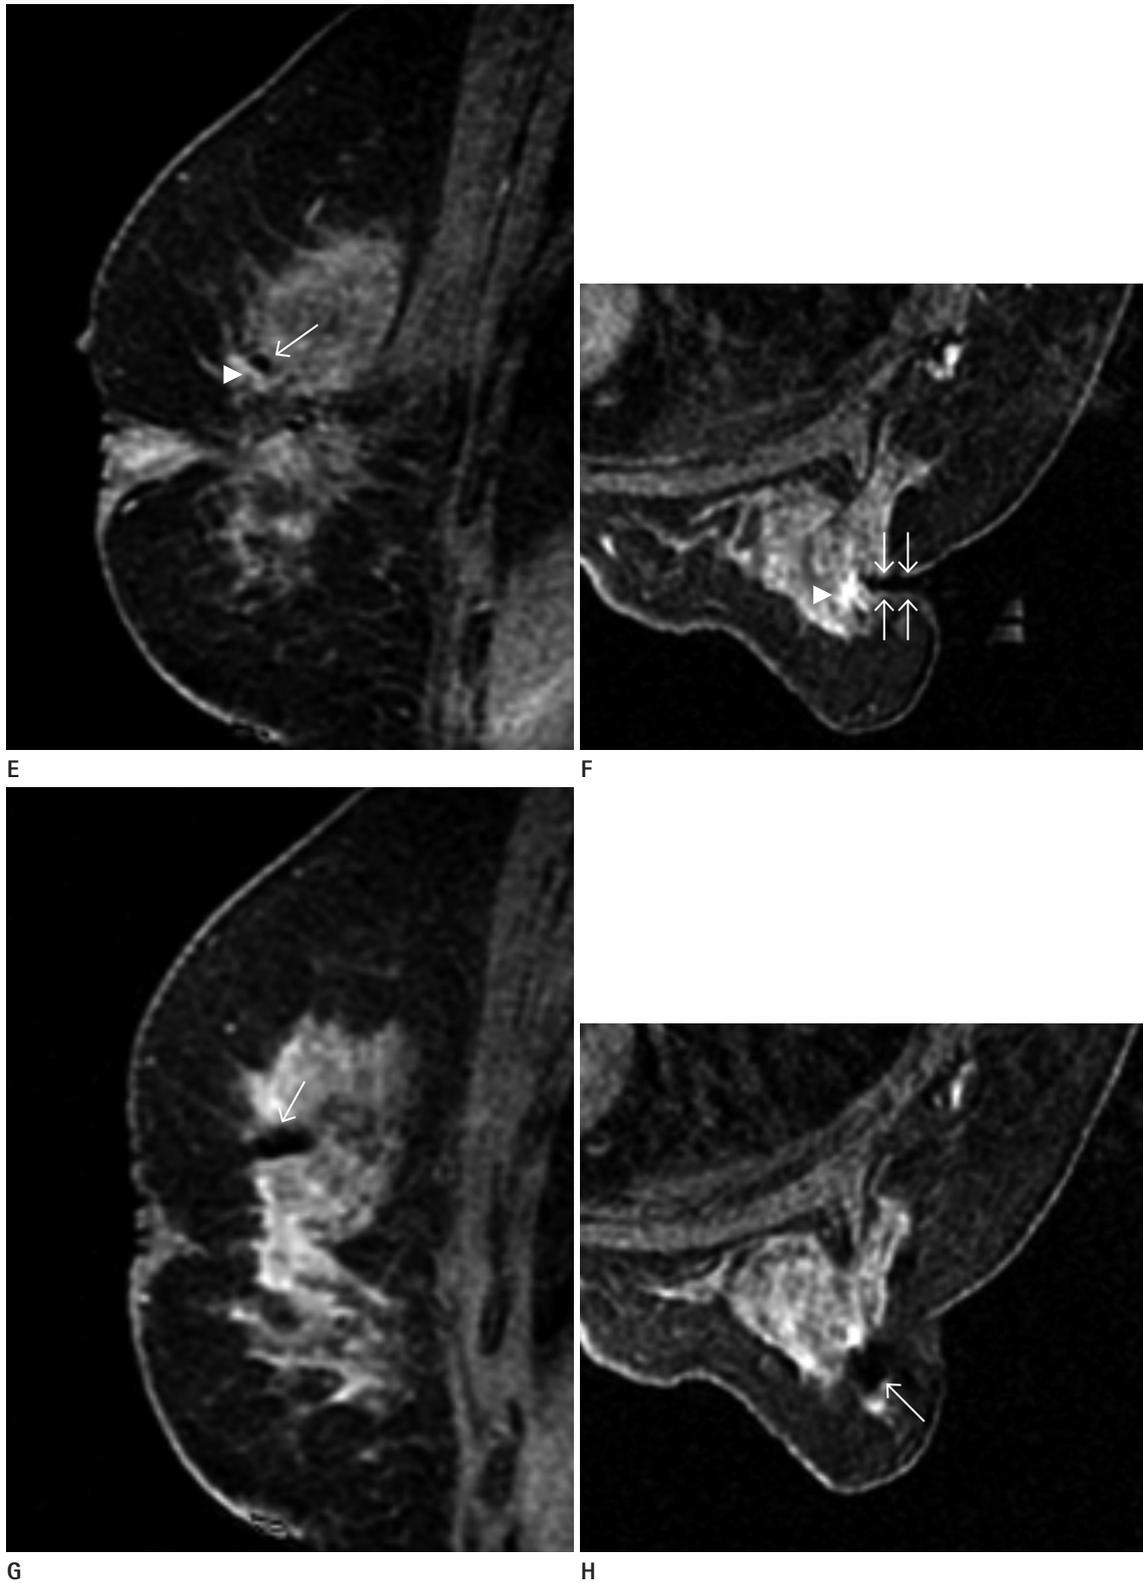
MRI-guided VAB procedure. After location of introducer sheath and obturator, sagittal and axial images (E, F) are obtained to confirm the position before lesion sampling. The target lesion (arrowhead) and obturator (arrow) are well demonstrated in these images. After tissue sampling, additional sagittal and axial images (G, H) are obtained to confirm adequate biopsy location and marker (arrow) placement. The target lesion was confirmed as ductal carcinoma *in situ*. VAB = vacuum assisted biopsy
